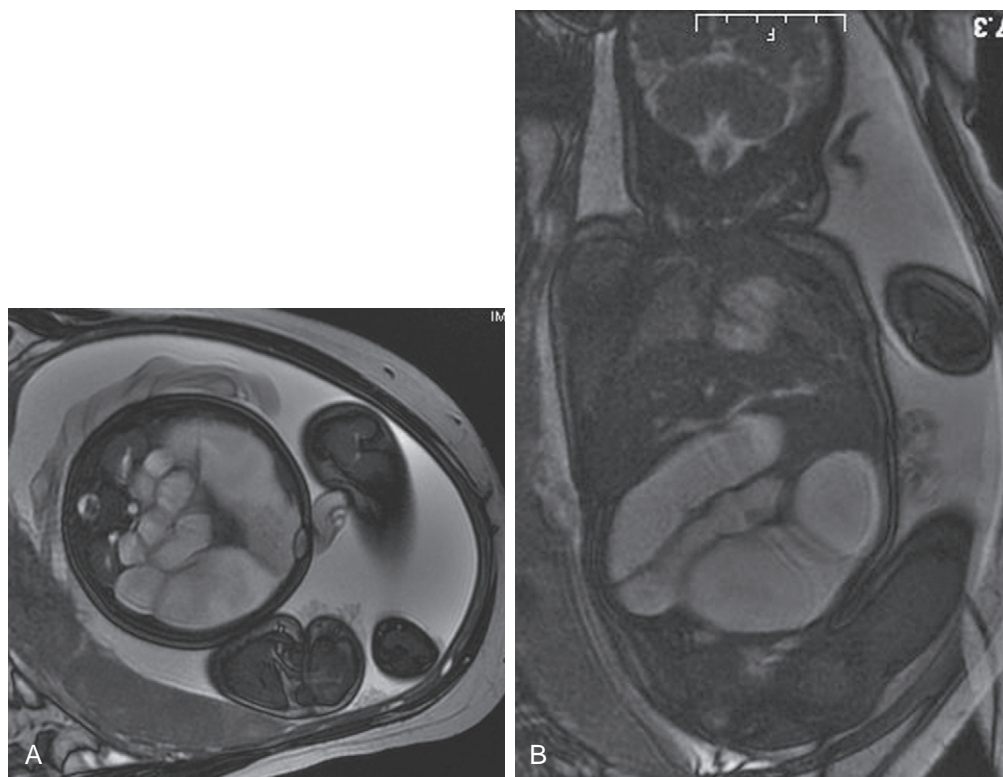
Fetal magnetic resonance imaging (MRI). A, Axial. B, Coronal. Prenatal ultrasound demonstrated a bowel obstruction. MRI shows multiple dilated, fluid-filled bowel loops with no meconium. Findings are suggestive of distal bowel obstruction.
